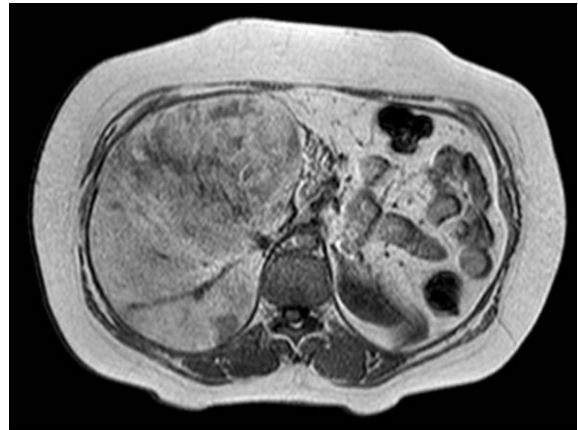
In axial T1 weighted in-phase gradient echo abdominal MR image reveals a left adrenal tissue mass with high signal intensity, suggesting fat component in the lesion. There is also low signal intensity areas suggesting hematopoietic tissue or hemorrhage.
